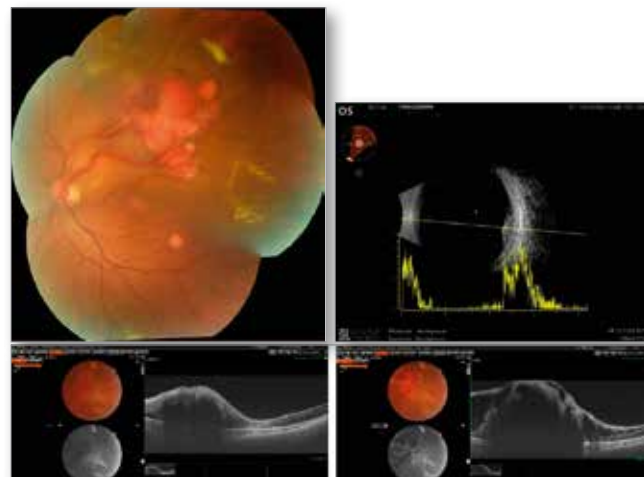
Capillary haemangioma colour picture, ultrasound, and OCT examination.
